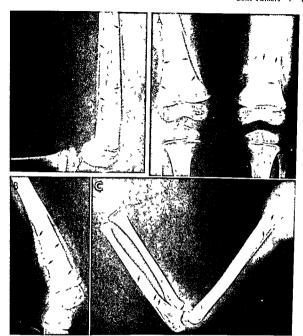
771 (above left) -Low grade osteomyel tis which resembles Ewing's tumor roentgenographically. In the middle third of the femoral shaft is a long segment of moth eaten destruction
